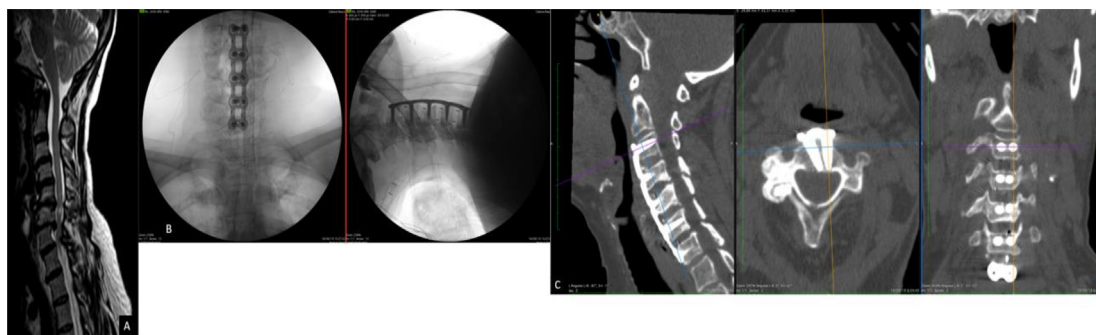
Image A shows the initial MRI before anterior cervical instrumentation that was performed due to cervical spondylotic myelopathy from C3–C7. Image B shows the final construct and realignment of the cervical lordosis in the projections AP and lateral postoperative. Image C shows the cervical spine simple tomography in the bone view where the proper placement of the C3 cervical screws in multiplanar reconstruction is observed.
